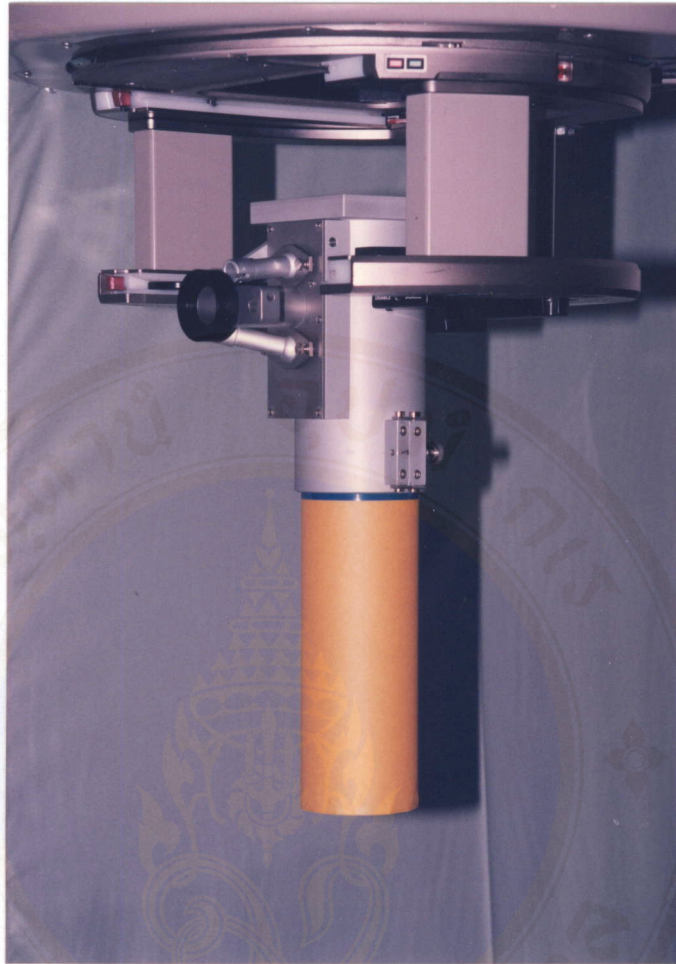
The irradiation technique in the determination of the maximum leakage outside an IORT cone by using a radiographic film.
